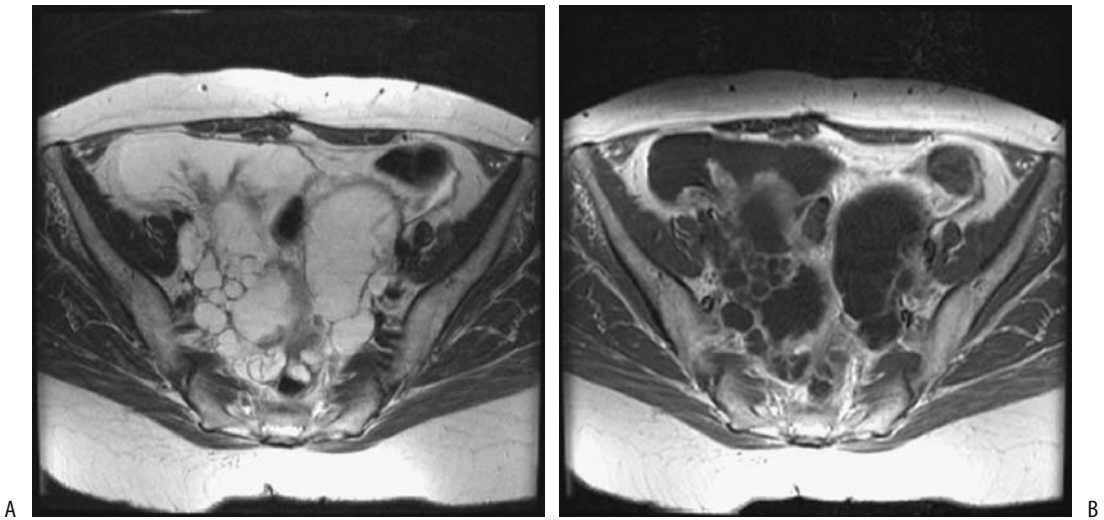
Pseudomyxoma peritonei. A: Transverse fast spin echo (FSE) T2-weighted magnetic resonance (MR) image identifies a hyperintense tumor. B: Enhancement of solid component is evident on postcontrast fat-saturated T1-weighted image. (Source: Szklaruk J, Tamm EP, Choi H, Varavithya V. Magnetic resonance imaging of common and uncommon large pelvic masses. *RadioGraphics* 2003;23:403–424, with permission from the Radiological Society of North America.)
